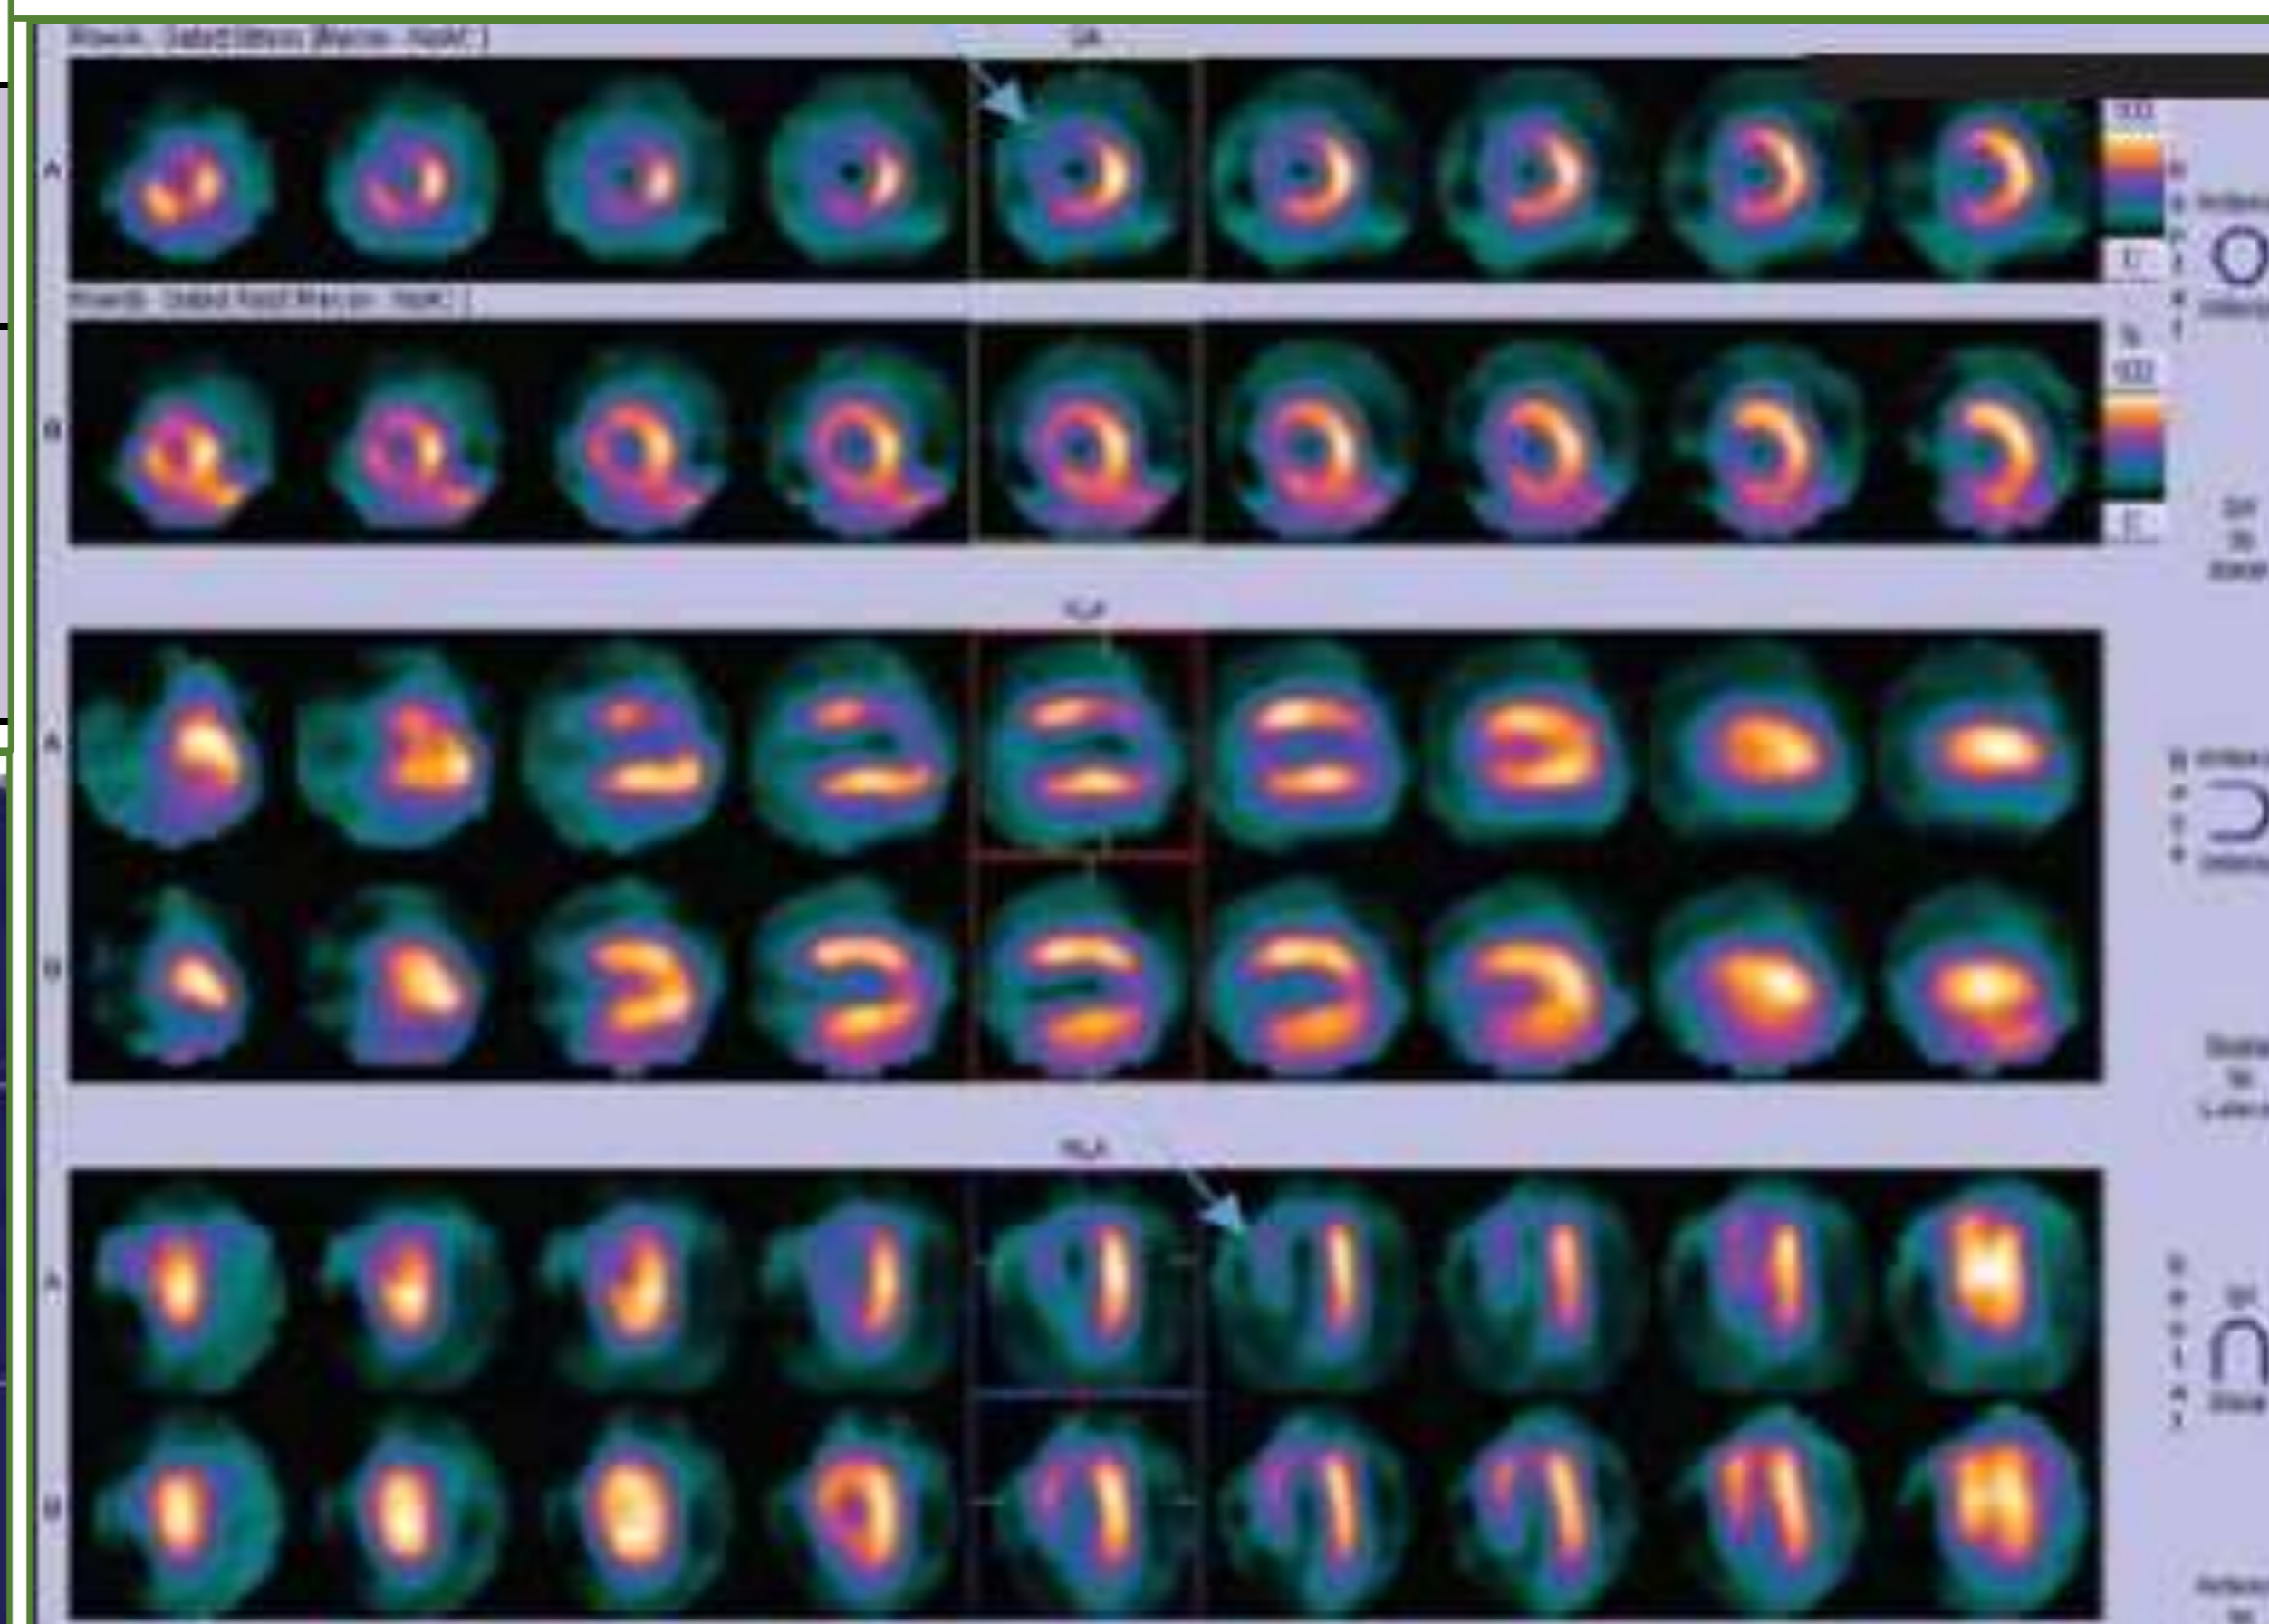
GMPI-SPECT Cardiac Stress image.
